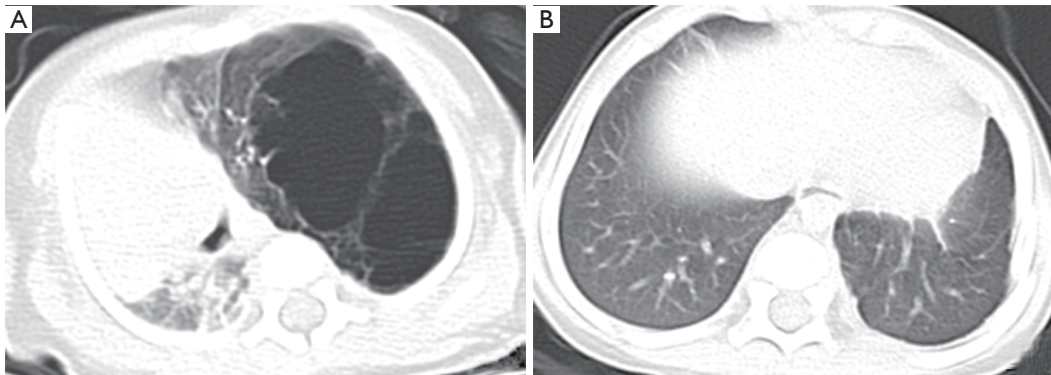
A 31-day-old boy with CPAM in the upper lobe of the left lung, Stocker type 1. CT plain scan images showed that: (A) the giant vesicle caused the heart to move to the right; (B) 1 year after resection of the upper lobe of the left lung, there was no residual lesion, and the heart returned to its original position. CPAM, congenital pulmonary airway malformation; CT, computerized tomography.
